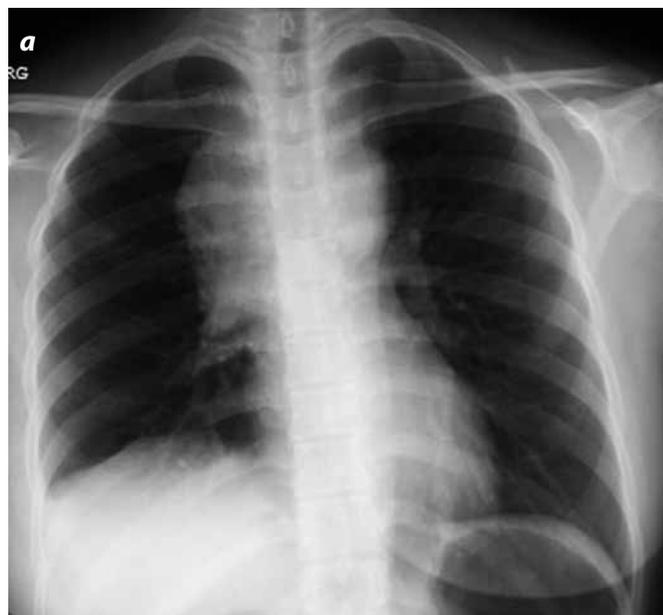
a and b). Radiography of the thorax, PA and lateral projection. Mediastinal engrossing due to lesion in the anterior mediastinum.
